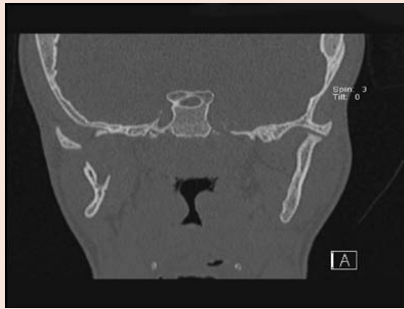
CT-coronal image shows hypoplasia of the vertical and horizontal branch of the mandible.
